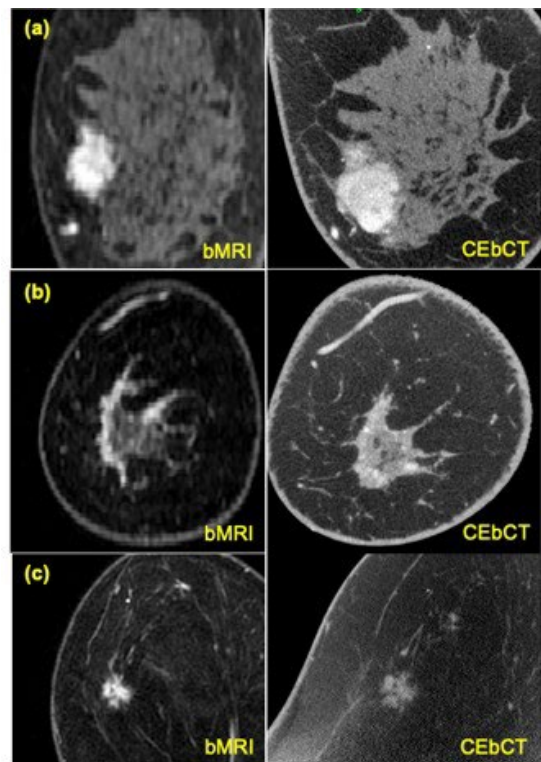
Patient examples of CEbCT and MRI images showing (a) an invasive mammary carcinoma in the coronal plane, (b) a benign lobular carcinoma in situ in the coronal plane, and (c) an invasive mammary carcinoma in the axial plane.
